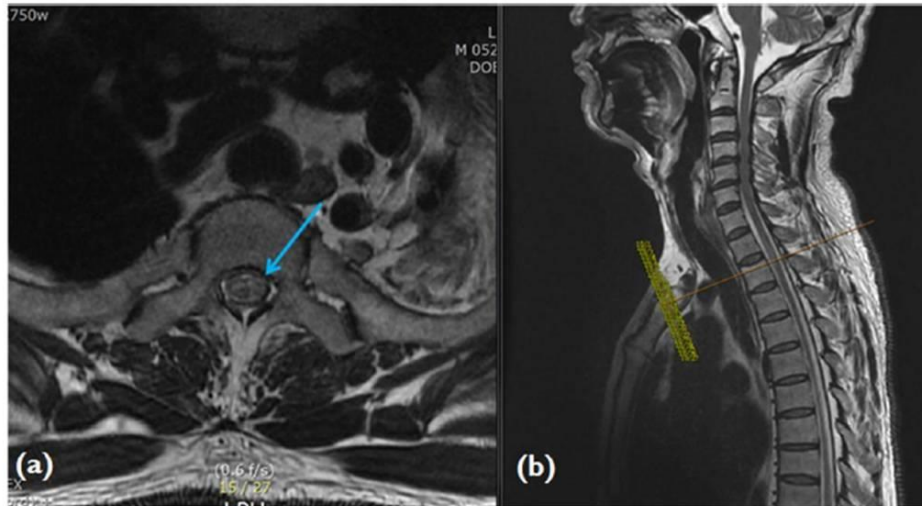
Whole spine MRI revealed abnormal T2 high signal at the anterior spinal cord at T1-T2 levels. (a) T2 high-resolution axial weighted image at T2 level (b) T2 high-resolution sagittal weighted image at T2 level
